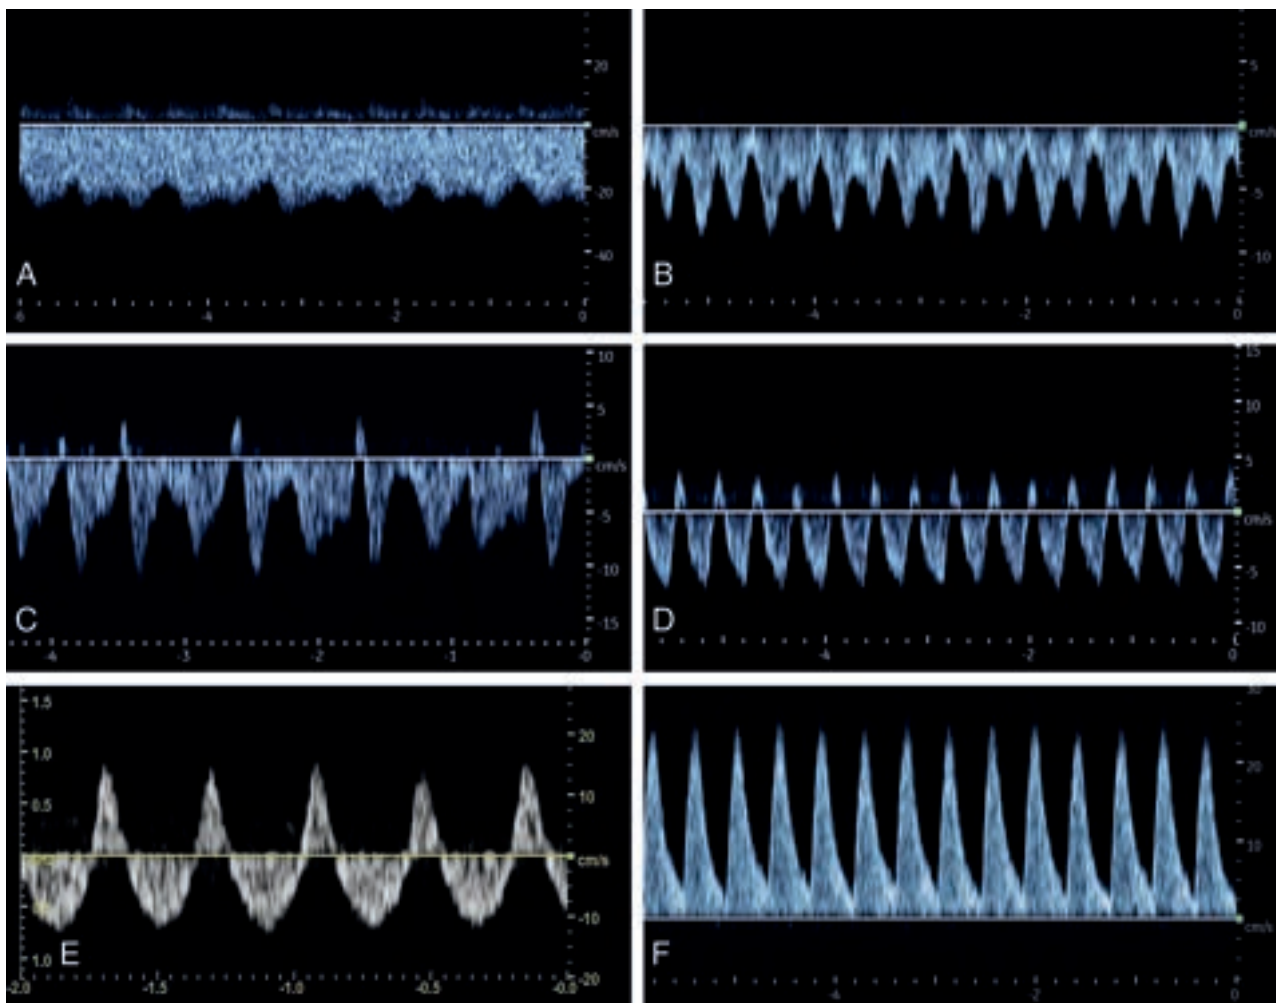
Classification of Doppler FPs of the SSS in neonates with vein of Galen malformation. *A*, FP1: Doppler FP with low fluctuation, minimum velocity, never less than half of the maximum velocity. *B*, FP2: Increased fluctuations of the flow velocities with minimum velocity less than half of the maximum velocity. *C*, FP3: Doppler FP with intermittent retrograde flow. *D*, FP4: Doppler FP with pulsatile retrograde flow. *E*, FP5: Doppler FP with a high retrograde flow (equal or more than one-third retrograde flow of the total Doppler flow). *F*, FP6: Doppler FP with complete retrograde flow.
